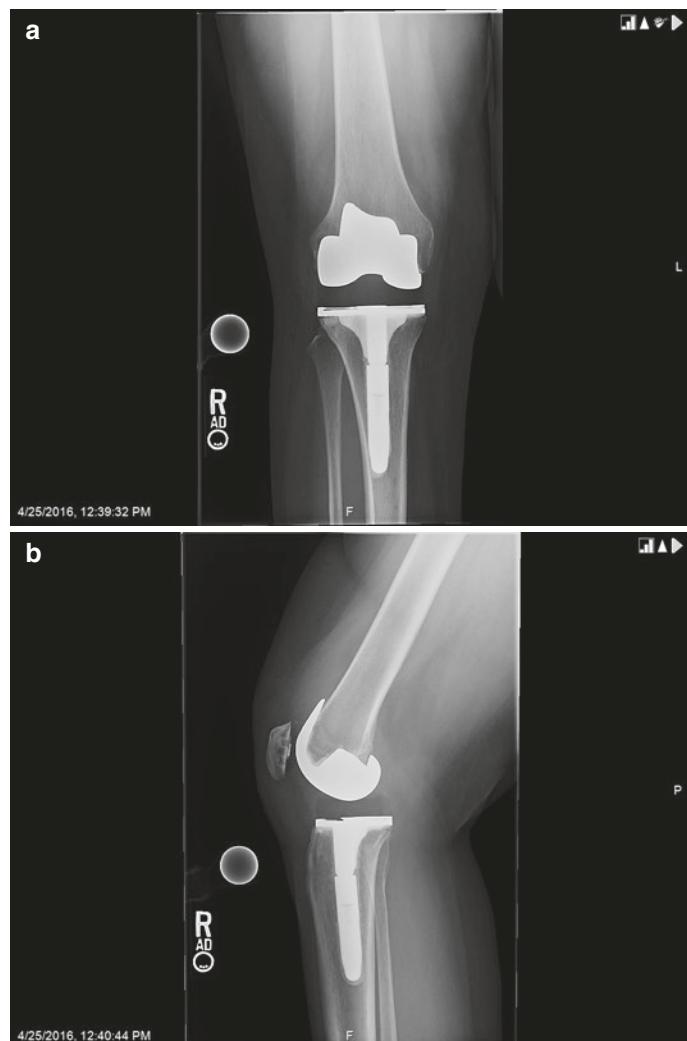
Postoperative revision x-rays showing a stemmed tibial component and good alignment
